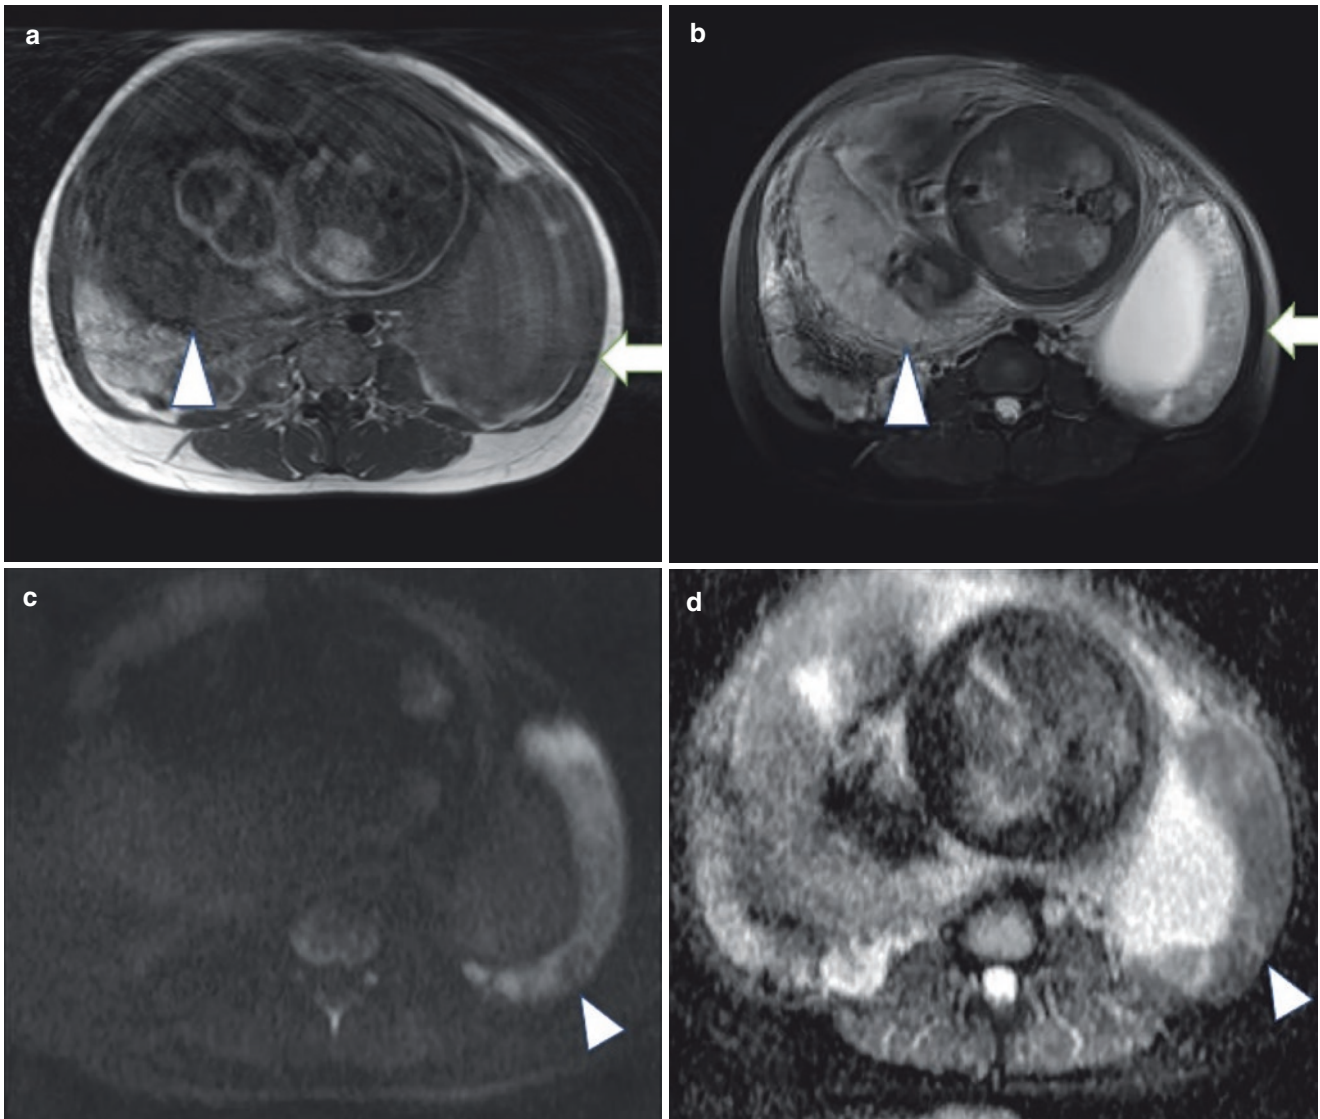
A 25-year-old woman. A woman with a 38 gestational week fetus was accidentally reported a pelvic mass during her routine ultrasonography screening. The surgery was performed after delivery, and pregnancy luteoma was reported. In the left lower abdomen, there was cystic mass (arrow) besides the pregnant uterus (arrowhead), which
